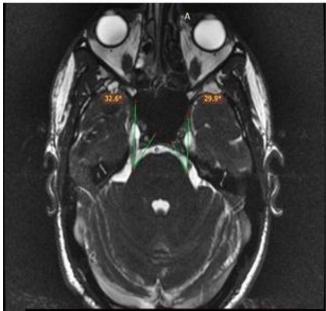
MRI brain of case number 1.
